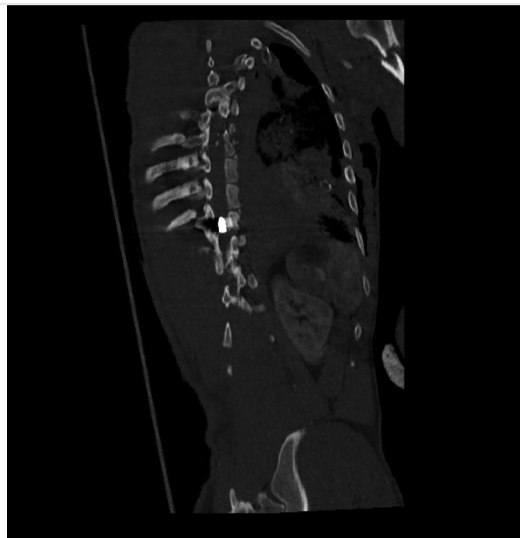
Sagittal computed tomography scan shows the bullet lodged within the spinal canal at T10 level
